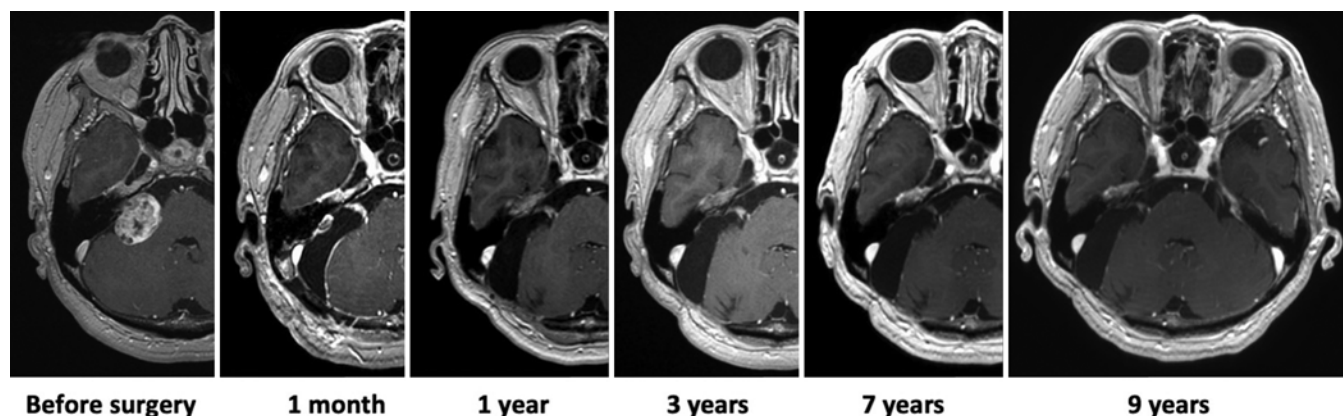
Representative case with tumor regression following surgery. This 59-year-old woman presented with a Koos grade IV VS in the right cerebellopontine angle. We left the tumor along the facial nerve, which fanned out in the cisternal portion. The Gd-enhanced lesion on axial MRI gradually shrank during follow-up after surgery.
